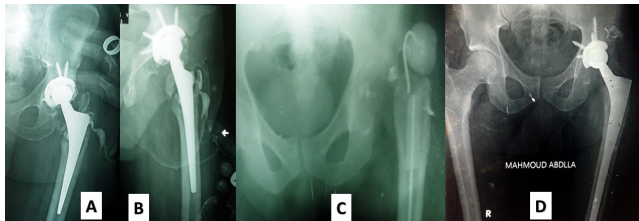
Male patient 38 years old with infected total hip; A and B) X-ray with sinogram showing infected total hip; C) X-ray before second operation; D) X-ray 3 years after revision with cement less long stem.
